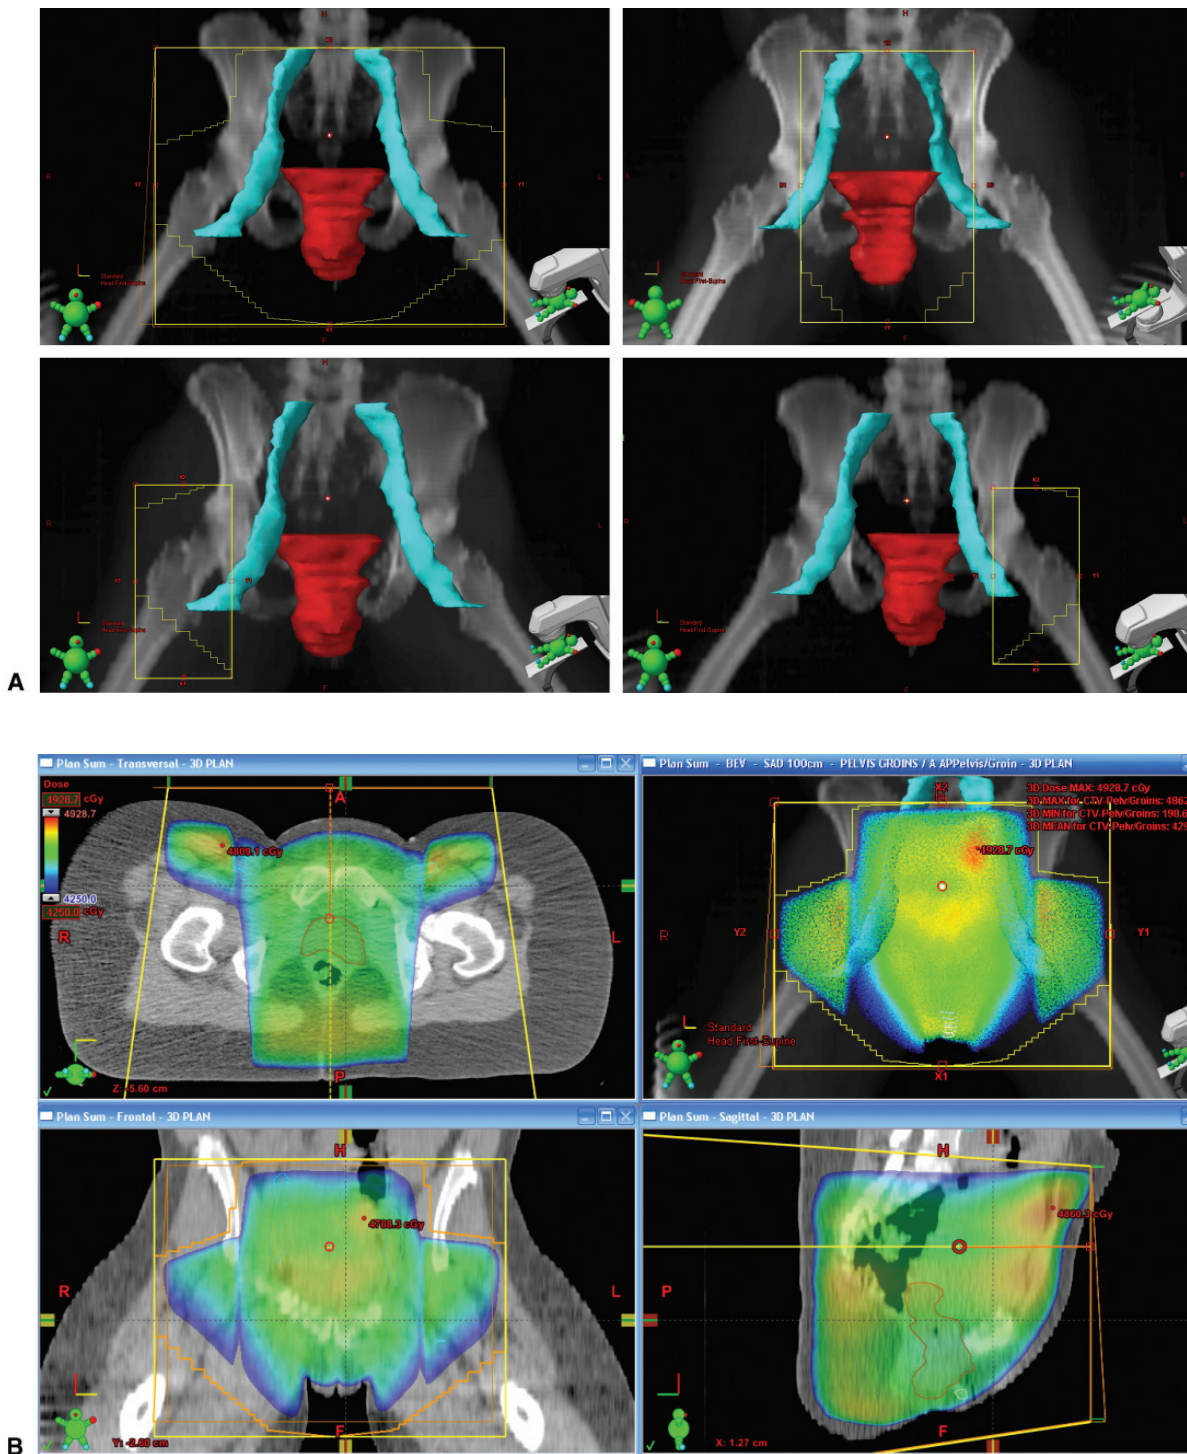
Vaginal cancer with distal third vaginal involvement, squamous cell carcinoma. Technique for pelvic and inguinofemoral nodal irradiation. A: Digital reconstructed radiographs. AP field intended to treat pelvis and groins; PA field intended to treat the pelvis only, in order to decrease the dose to the femoral heads; small AP photon field for additional daily boost to the inguinofemoral nodes. B: Axial, sagittal, and coronal isodose distributions.
